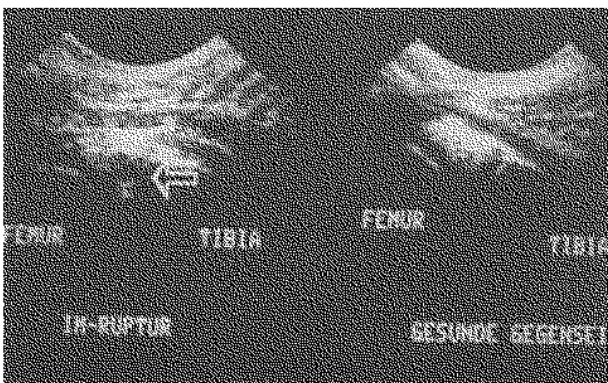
Ultrasonographic image of a lesion of the medial meniscus. The dark area in the echogenic structure (white arrow) represents the rupture. The lesion was confirmed arthroscopically.
